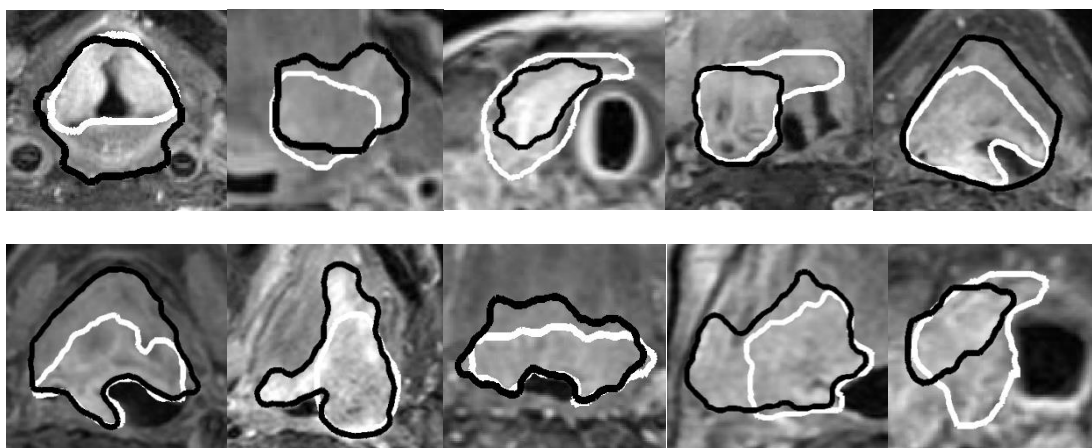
10 axial MRI slices from different patients demonstrating worst agreement (DSC: 0.6-0.7) between C-auto (black outline) and C-gold (white outline) outlines
